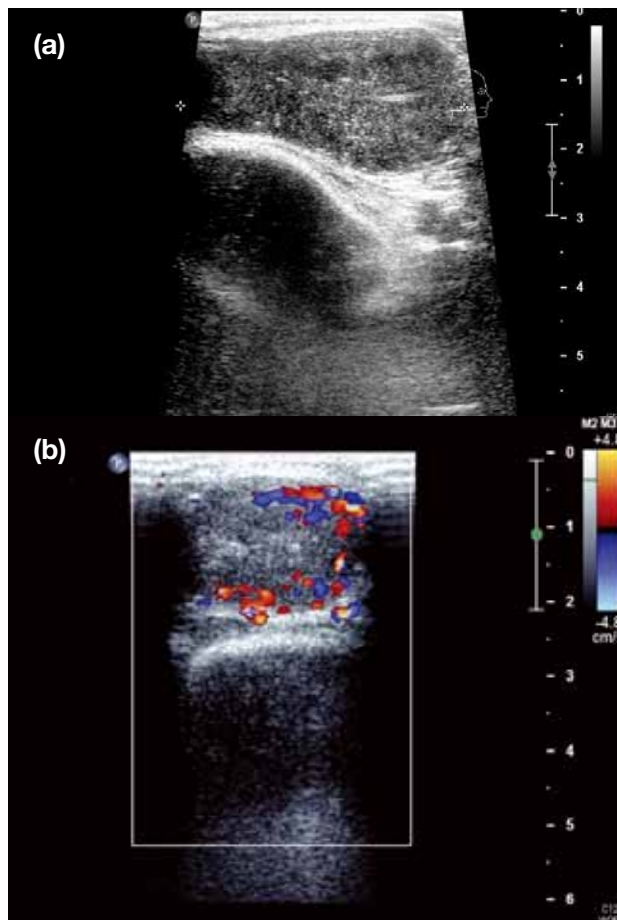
An ultrasound study of right suboccipital mass. (a) Longitudinal scan, the slightly hyperechoic solid mass appears well-margined and is positioned within the deep subcutaneous plane closely abutting the underlying musculature. (b) Transverse scan with colour Doppler, showing foci of hypervascularity over the peripheral aspect of mass. Trucut core biopsy has subsequently been performed under ultrasound guidance.
